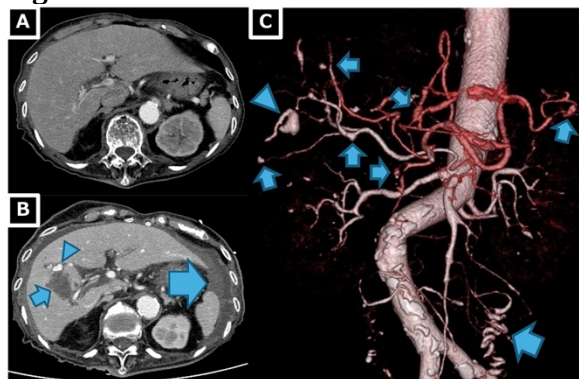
(A) Contrast-enhanced CT scan in arterial phase: No abnormality of visceral arteries on admission. (B) Contrast-enhanced CT scan in arterial phase: an aneurysm (60 × 25 × 70 mm, arrowhead) and a hematoma (small arrow) in the right liver lobe and hemorrhagic ascites (large arrow) on the 11th day. (C) 3D-CT angiography (reconstruction of CT on the 11th day): Multiple microaneurysms (arrows) in the hepatic, splenic, superior pancreaticoduodenal and ovarian arteries, notably a ruptured aneurysm (arrowhead) in the right hepatic artery.
